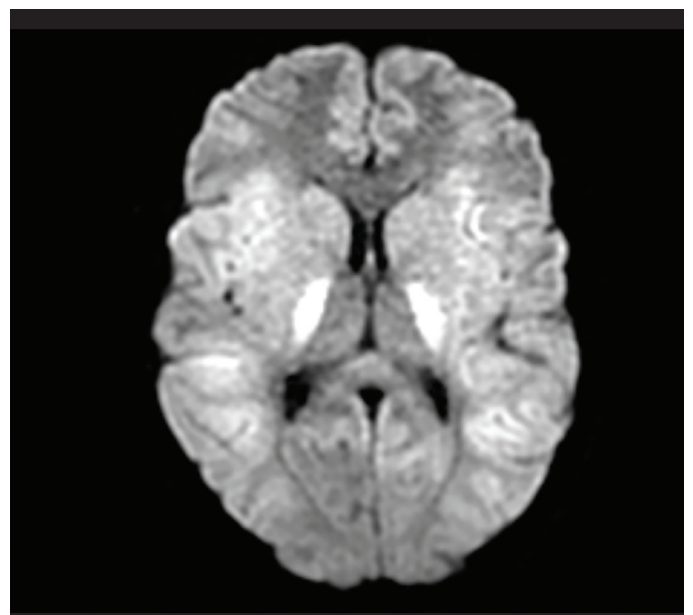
Cranial magnetic resonance imaging (MRI) findings. Brain MRI obtained on hospital day 5 demonstrating diffuse T2-weighted hyperintense signal abnormalities involving the bilateral thalami, basal ganglia, and cerebral cortex, consistent with hypoxic-ischemic encephalopathy.
